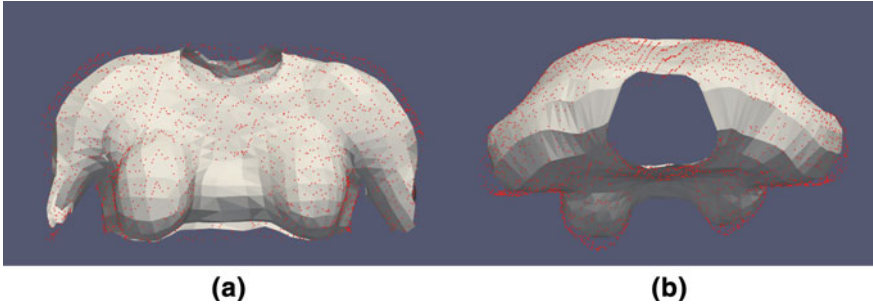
Refined mesh from the a anterior view and b superior view, where points are the segmented point clouds from a MR image acquired in the prone position
